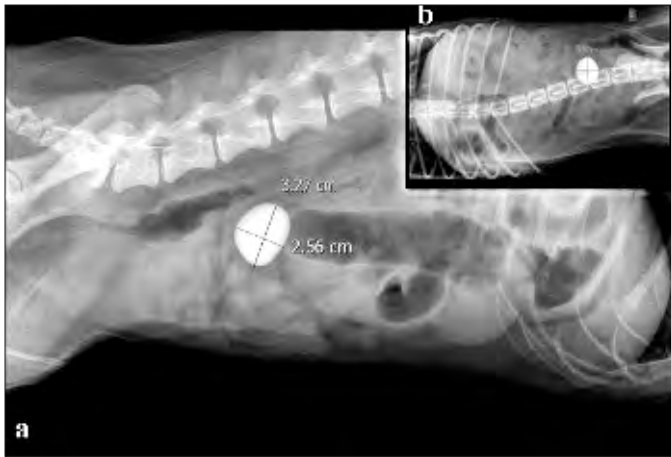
Radiograph before surgery; a) stone on right lateral view; b) stone on ventro-dorsal view
